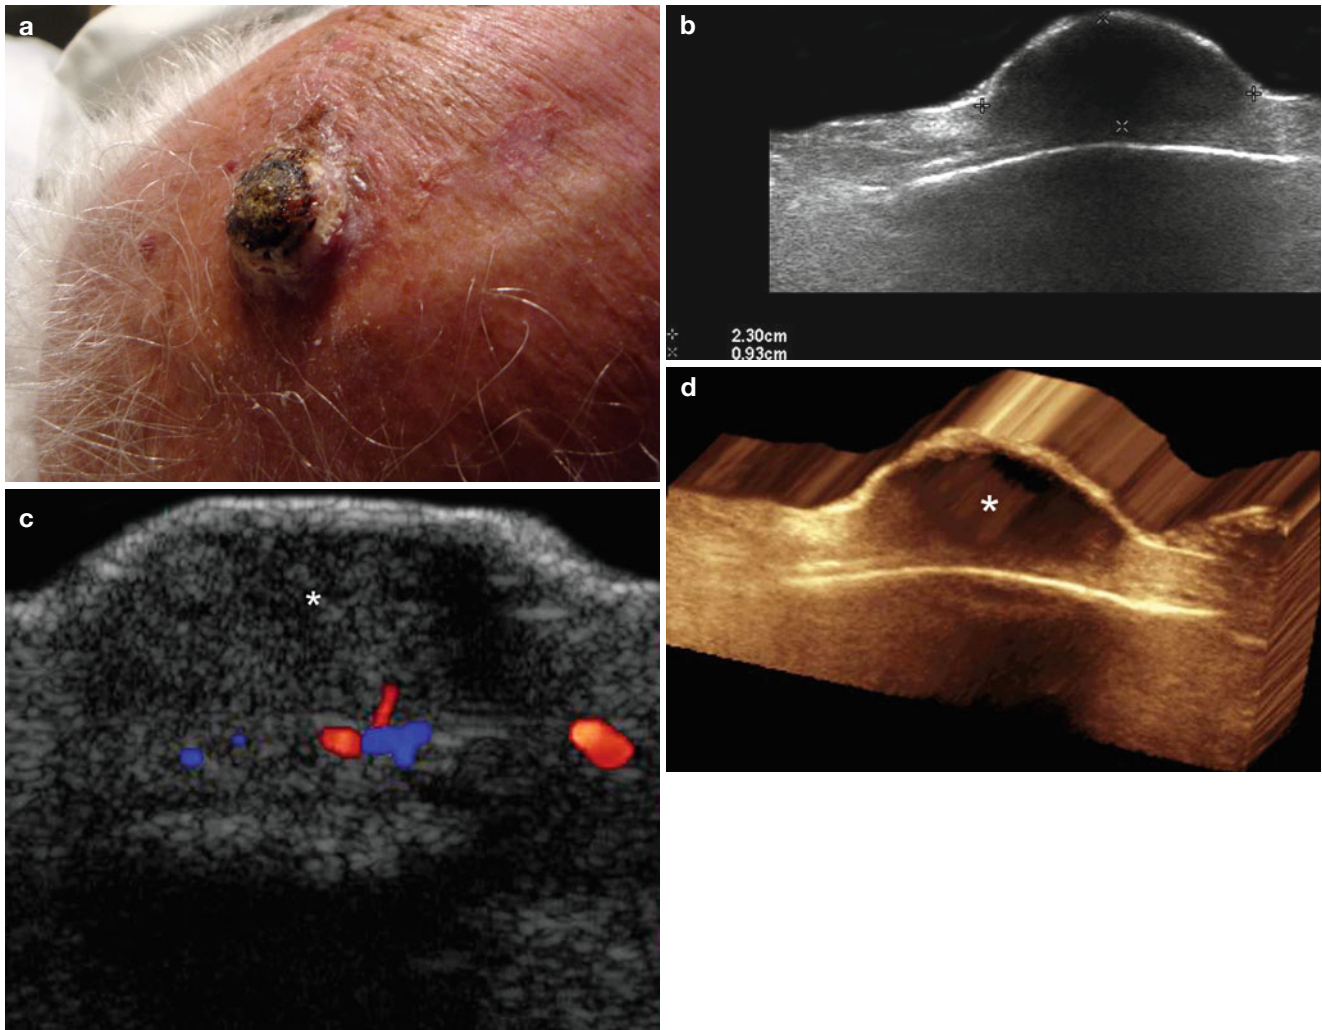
(a–c) Basal cell carcinoma. (a) Clinical image shows erythematous, pigmented, crusted, and scaly lesion in the right frontal region of the scalp. (b) Grey scale ultrasound image (transverse view) demonstrates a 2.88 cm (transverse)  $\times$  0.37 cm (depth) hypoechoic structure
